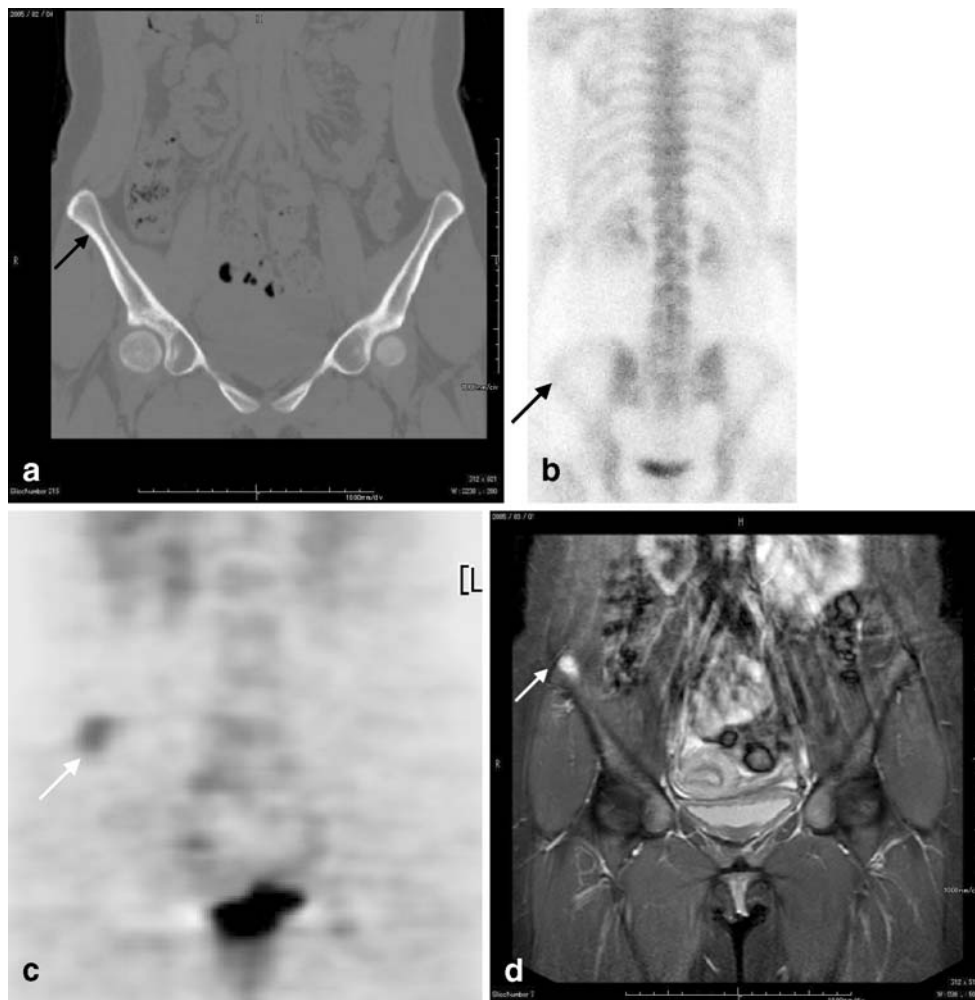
a Coronal CT image of an invisible metastasis in a 55-year-old woman after surgery for breast cancer. The metastasis should be present at the site indicated by the *arrow*, but could not be clearly seen. b Posterior bone scintigrams. Uptake in the ilium bone metastasis is unclear (*arrow*). c Coronal FDG-PET image. Uptake was seen in the ilium (*arrow*). This metastasis had a SUV_{mean} of 2.9. d Gadolinium-enhanced MR image with coronal fat suppression. Enhanced signal intensity is seen in the ilium (*arrow*), suggesting a bone metastasis. The lesion grew larger during follow-up, suggesting bone metastases clinically
